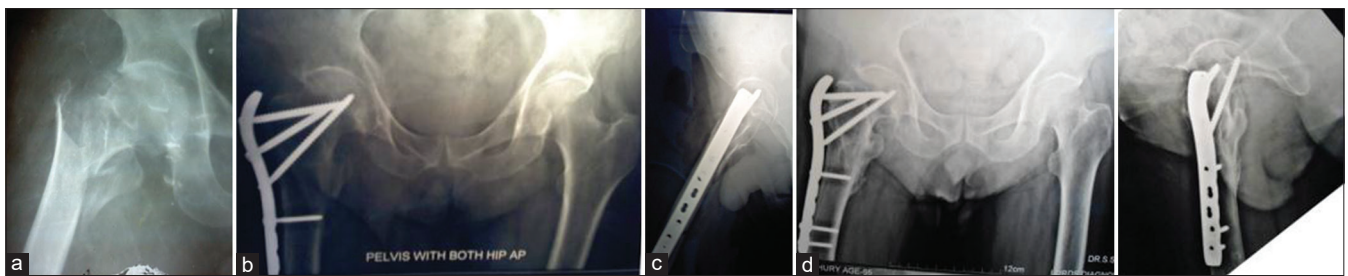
(a) Case 1 Pre-operative X-rayfig, (b) Immediate post-operative AP view, (c) Immediate post-operative lat view, (d) 3 months post-operative AP and lat view
